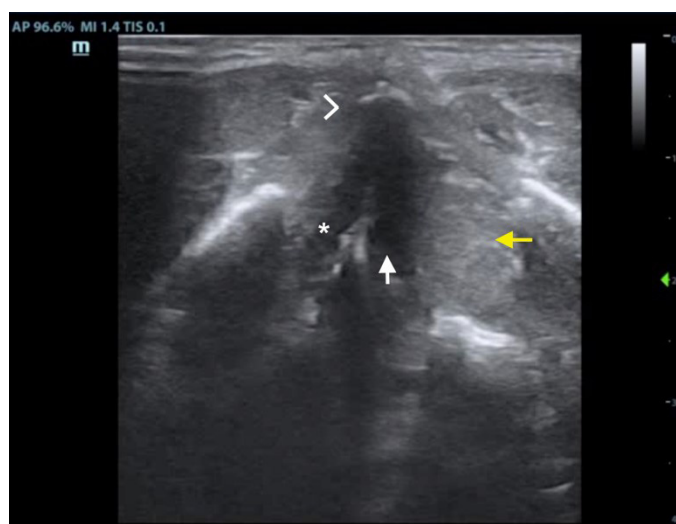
Transverse ultrasound image at the level of the vocal cords demonstrating a normal thyroid cartilage (arrowhead), normal right vocal cord (asterisk) and a soft tissue swelling consistent with hematoma (yellow arrow) lateral to the left vocal cord (white arrow).
